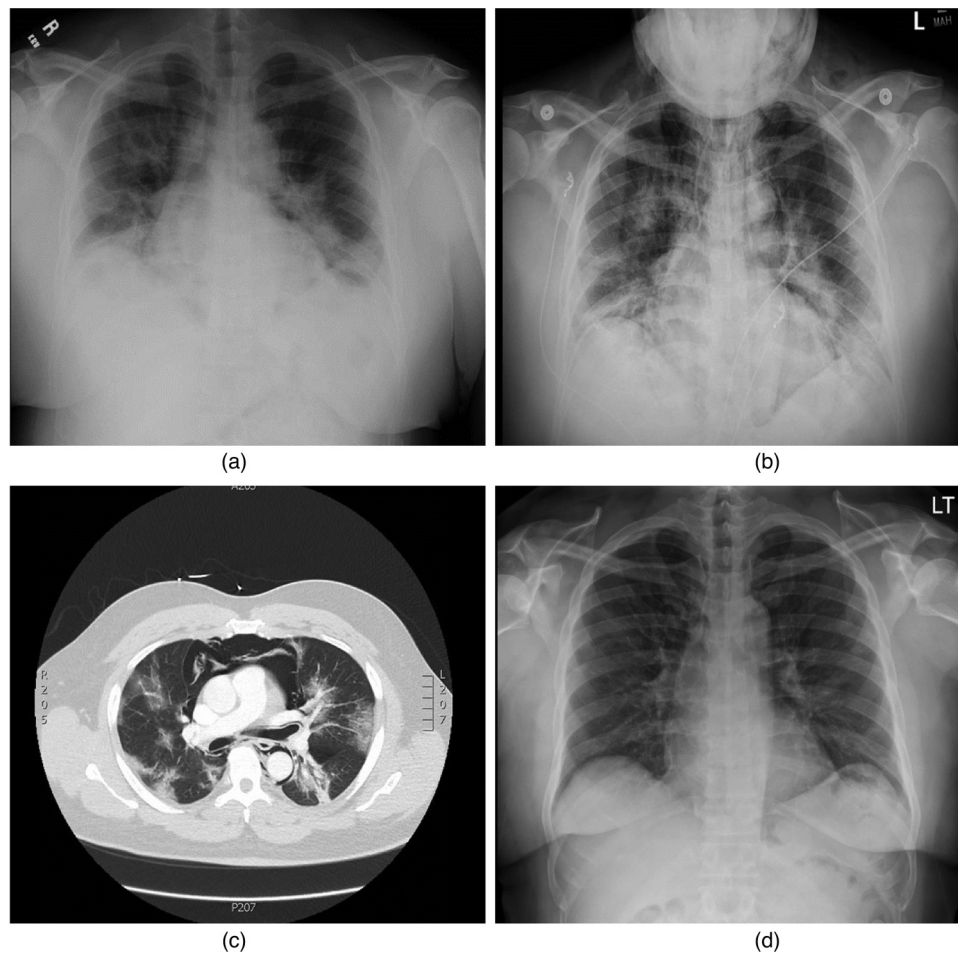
(a) Chest x-ray on admission. (b) Chest x-ray finding pneumomediastinum. (c) CT chest demonstrating pneumomediastinum. (d) Chest x-ray after discharge
